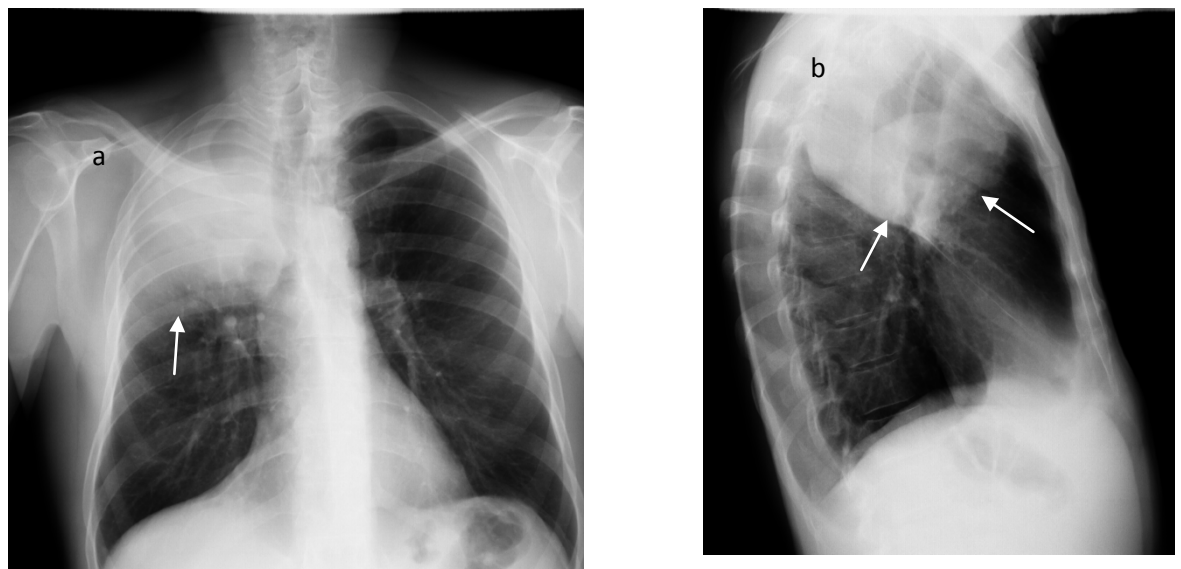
Frontal (a) and lateral (b) chest radiographs. In upper department of right pulmonary field homogeneous shadow with lower concave contour and without air bronchogram (arrows). Right upper lobe atelectasis caused by endobronchial lung cancer
